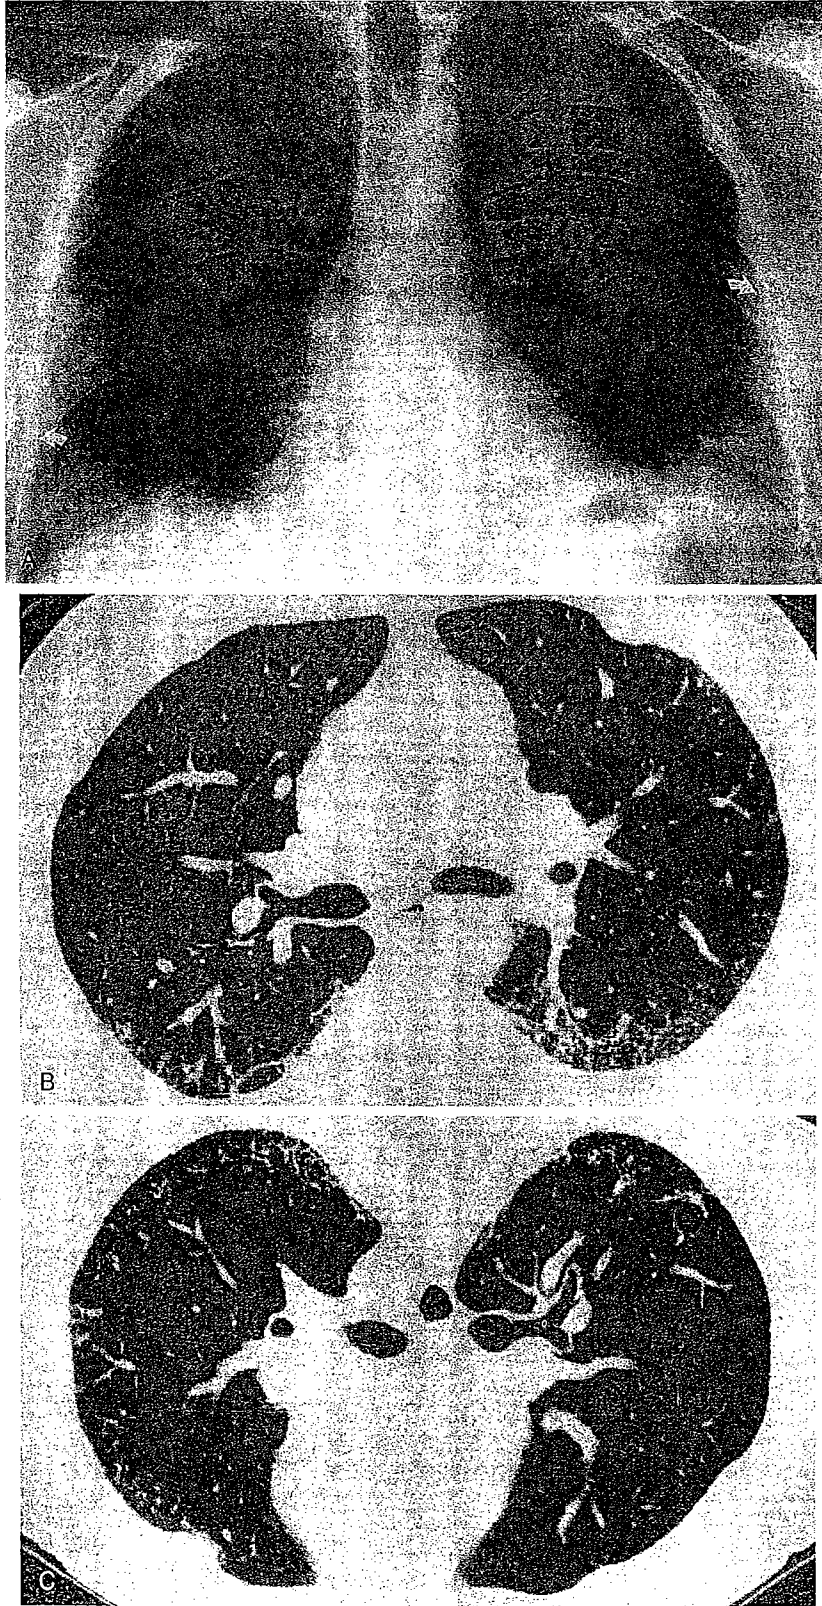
Asbestosis. A posteroanterior chest radiograph (A) in a 54-year-old shipyard worker demonstrates irregular linear opacities in the lower lung zones. Note associated low lung volumes and bilateral pleural plaques (arrows). HRCT scans in the supine (B) and prone (C) positions demonstrate irregular linear opacities involving predominantly the subpleural lung regions. The opacities represent both intralobular lines and thickening of interlobular septa. Localized areas of ground-glass attenuation in the subpleural lung regions are also evident.
